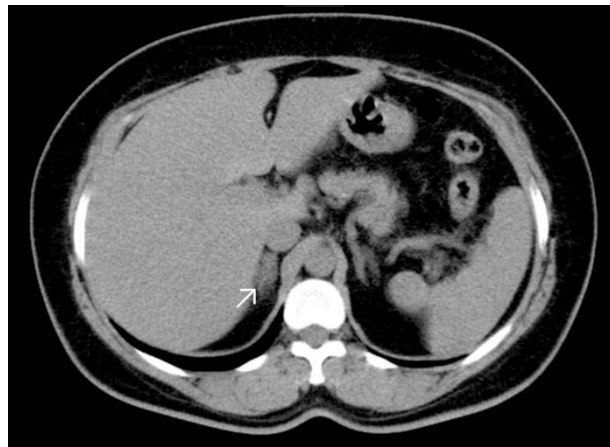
Axial contrast CT scan images: a)increased size in right adrenal gland because of haemorrhage (b)increased density in adjacent fat tissue
